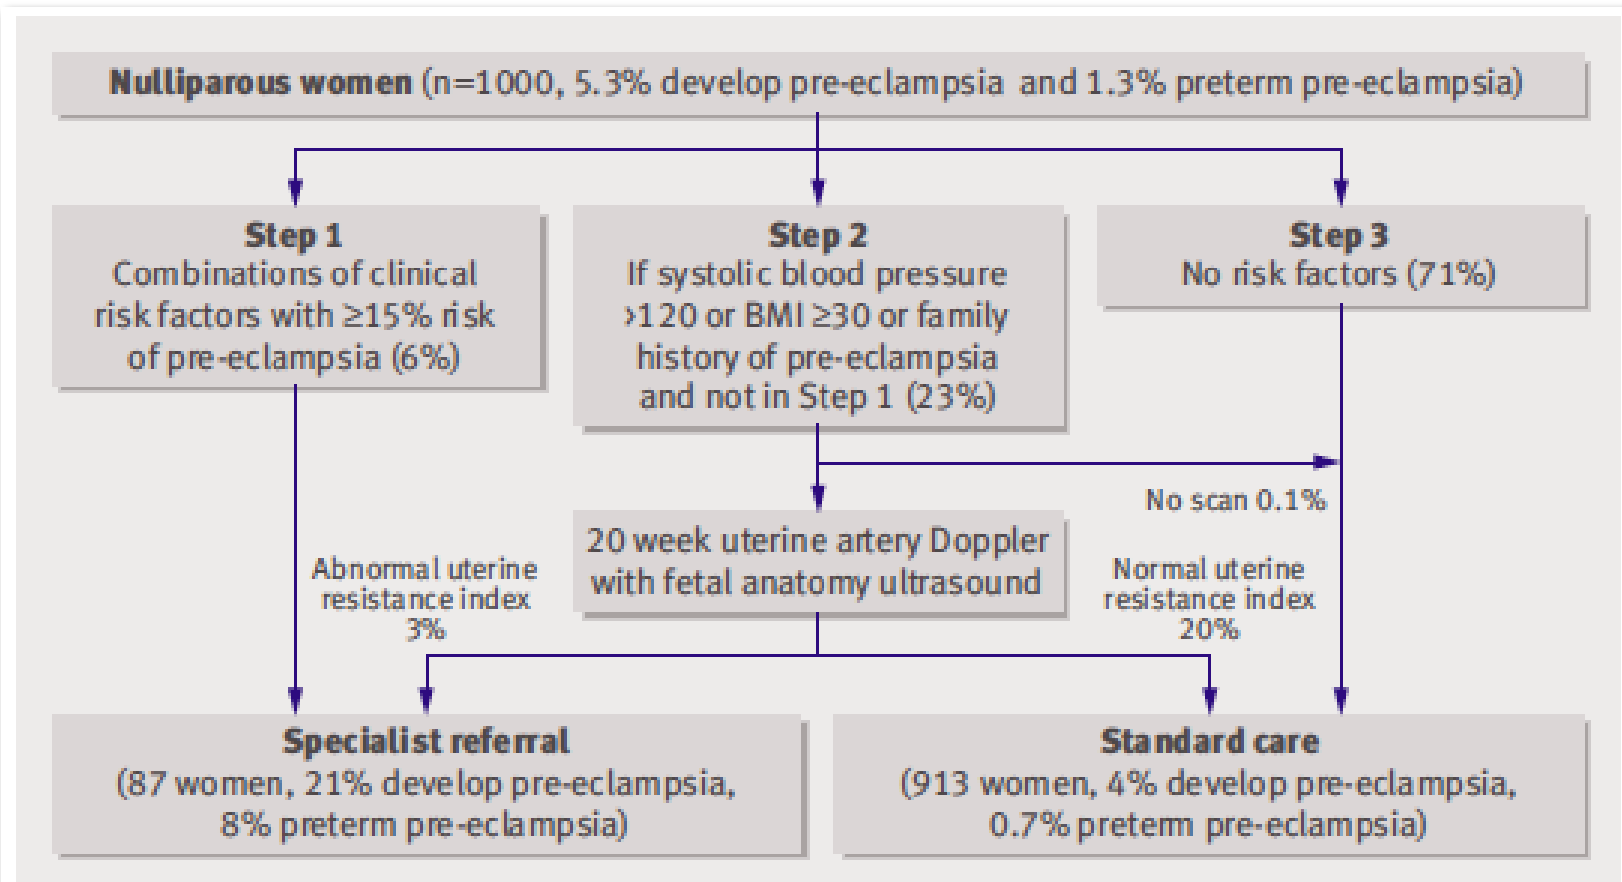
Framework for specialist referral when estimated risk of pre-eclampsia is $\geq 15\%$ in model or presence of clinical risk factor with abnormal result on uterine artery Doppler scan
